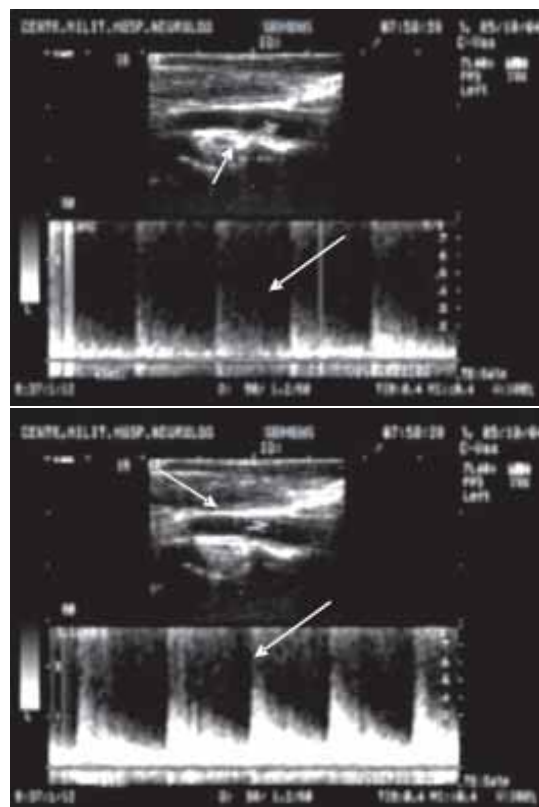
Echo – Doppler – a different flow pattern has been found in the 2 parts of the vessel separated by the septum (left – the “false” lumen, right – the artery lumen).
